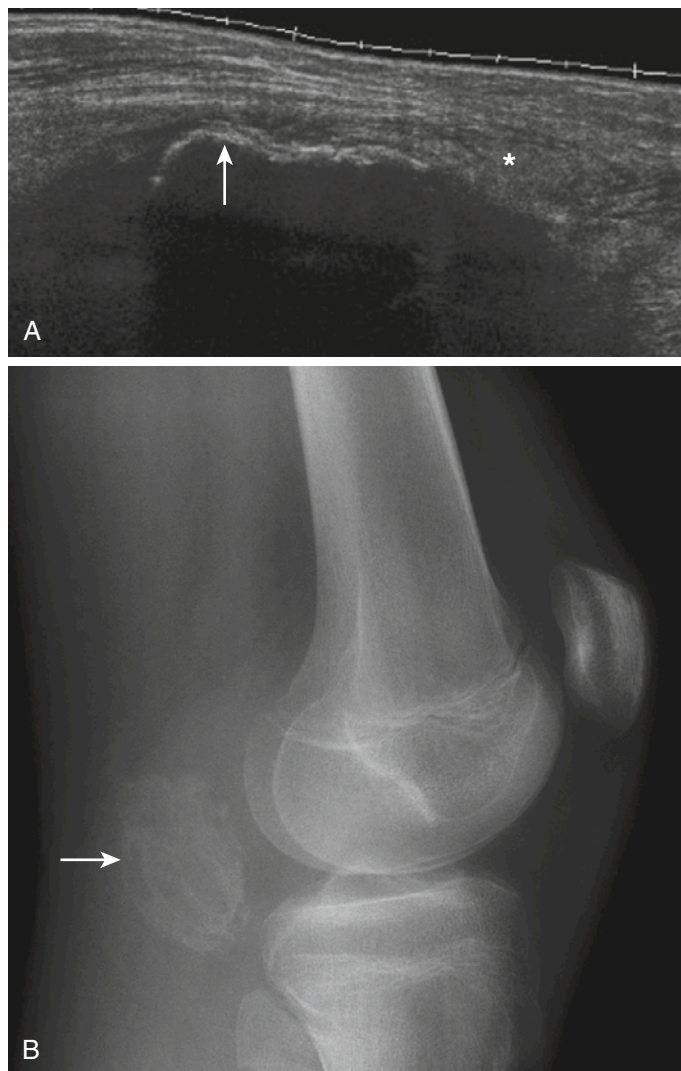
Myositis ossificans. A 14-year-old boy had posterior knee swelling and a history of minor trauma. The initial radiograph was normal, and subsequent MRI showed edematous swelling. A, Longitudinal panoramic sonogram view two weeks later shows a sheet of ossification (*arrow*) and minor adjacent soft tissue edema (*star*) with otherwise normal soft tissues. B, Myositis ossificans confirmed on the basis of a radiograph demonstrating a calcified mass (*arrow*) behind the knee. C, Subsequent axial CT images that show a soft tissue swelling with a mature peripheral ossification (*arrows*).
